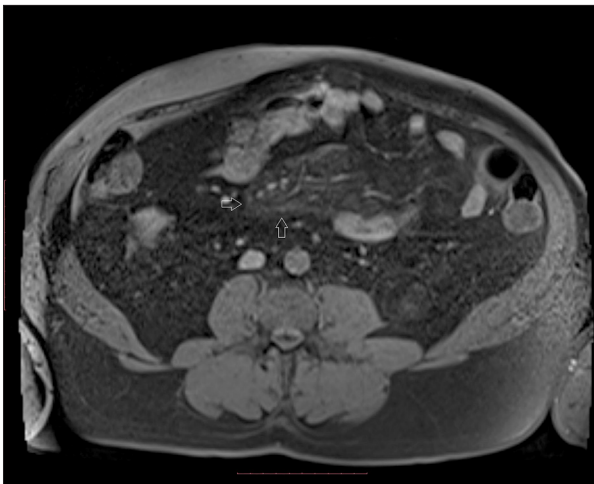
Control MRI study after treatment shows partial regression of the lesion, which is smaller and less demarcated (open arrows).
